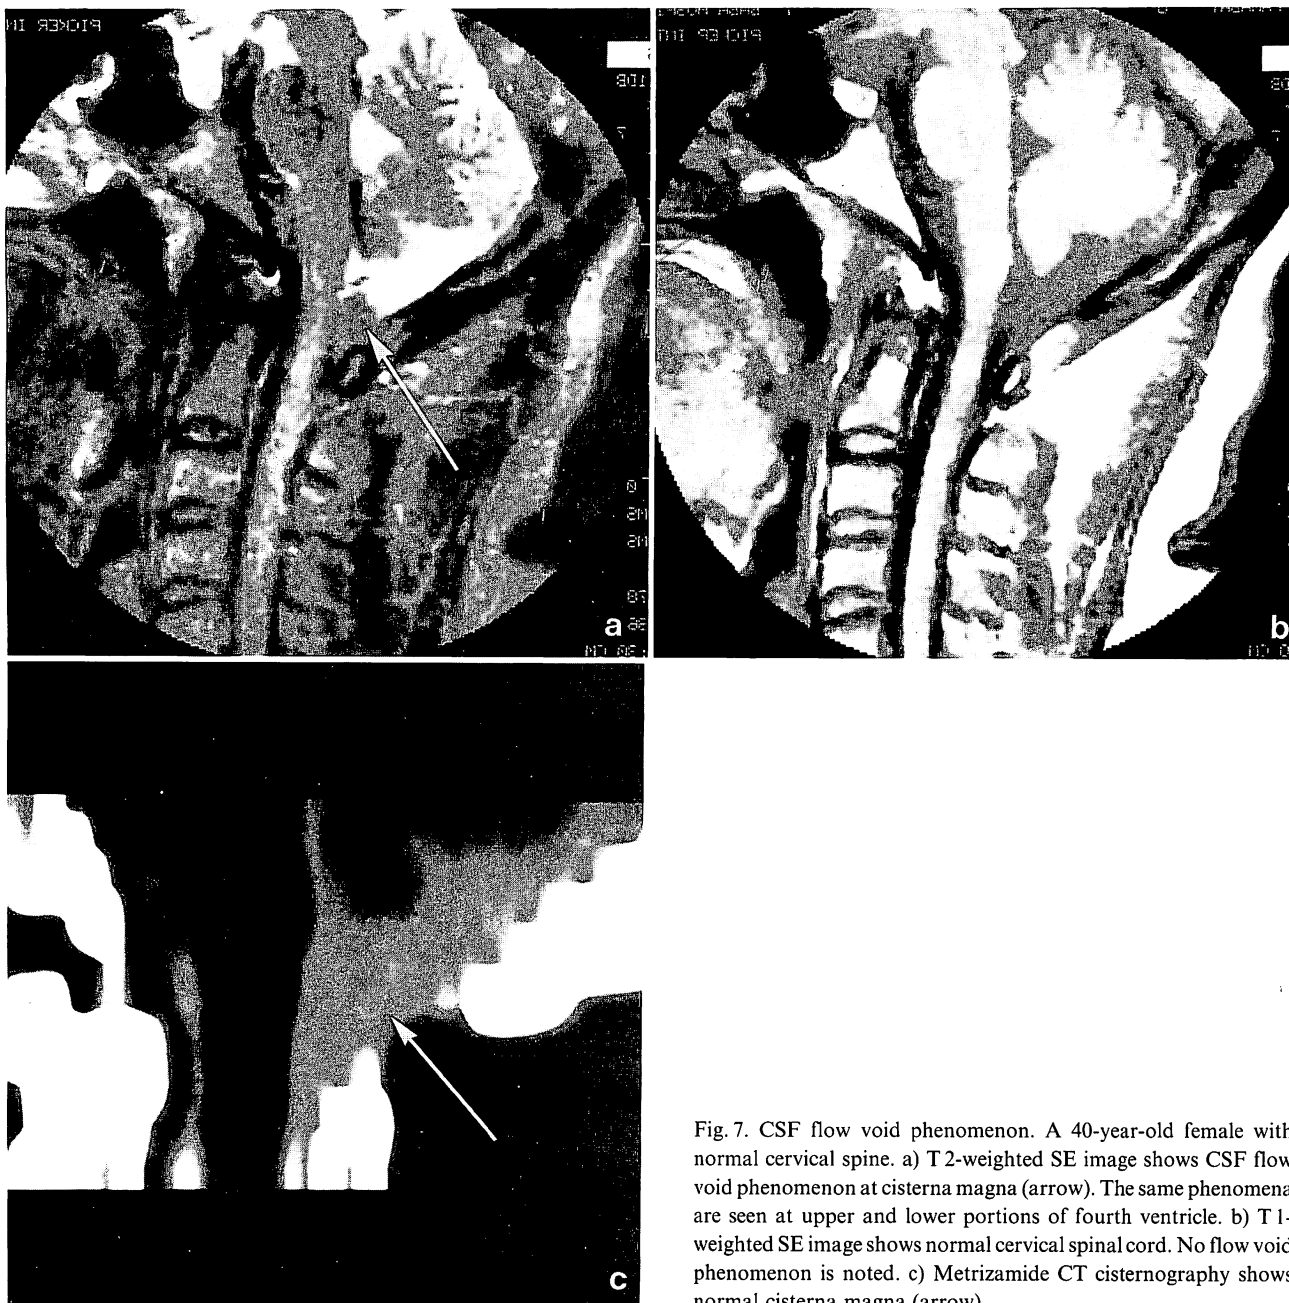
CSF flow void phenomenon. A 40-year-old female with normal cervical spine. a) T2-weighted SE image shows CSF flow void phenomenon at cisterna magna (arrow). The same phenomena are seen at upper and lower portions of fourth ventricle. b) T1-weighted SE image shows normal cervical spinal cord. No flow void phenomenon is noted. c) Metrizamide CT cisternography shows normal cisterna magna (arrow)
